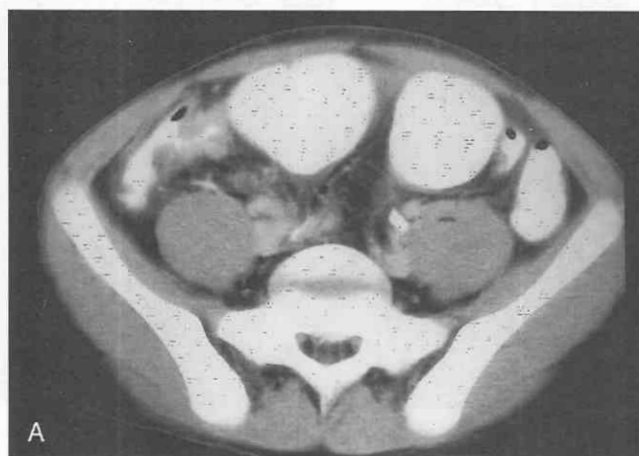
Crohn's disease. A, CT scan through the lower abdomen in a patient with Crohn's disease demonstrates thickening of the distal ileum. B, CT scan in the same patient 2 cm below A shows marked thickening of the distal ileum.
